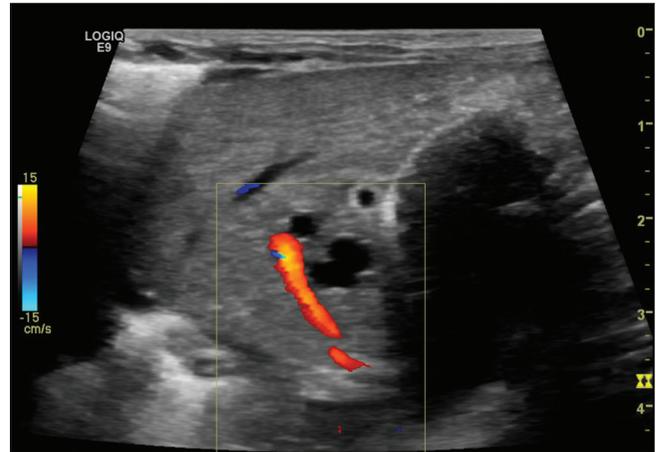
Abdominal ultrasound on day of life 28 demonstrating 6 mm cystic dilatation of the intrahepatic ducts
